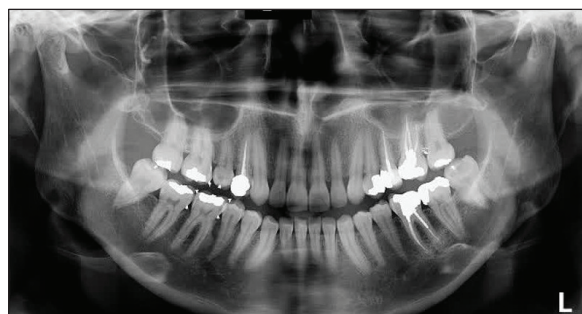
Postoperative control panoramic X-ray taken after eight months.
